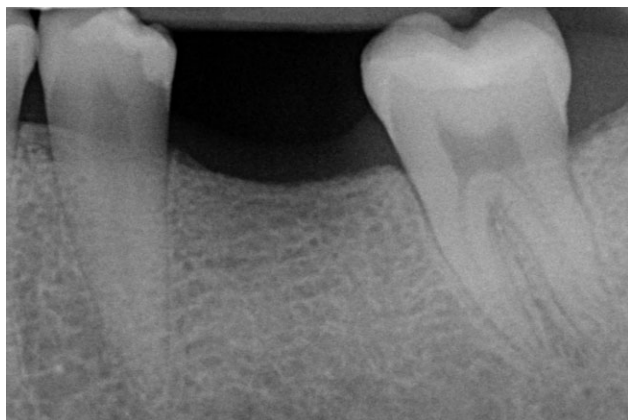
Preoperative: radiograph of a missing mandibular left first molar.
